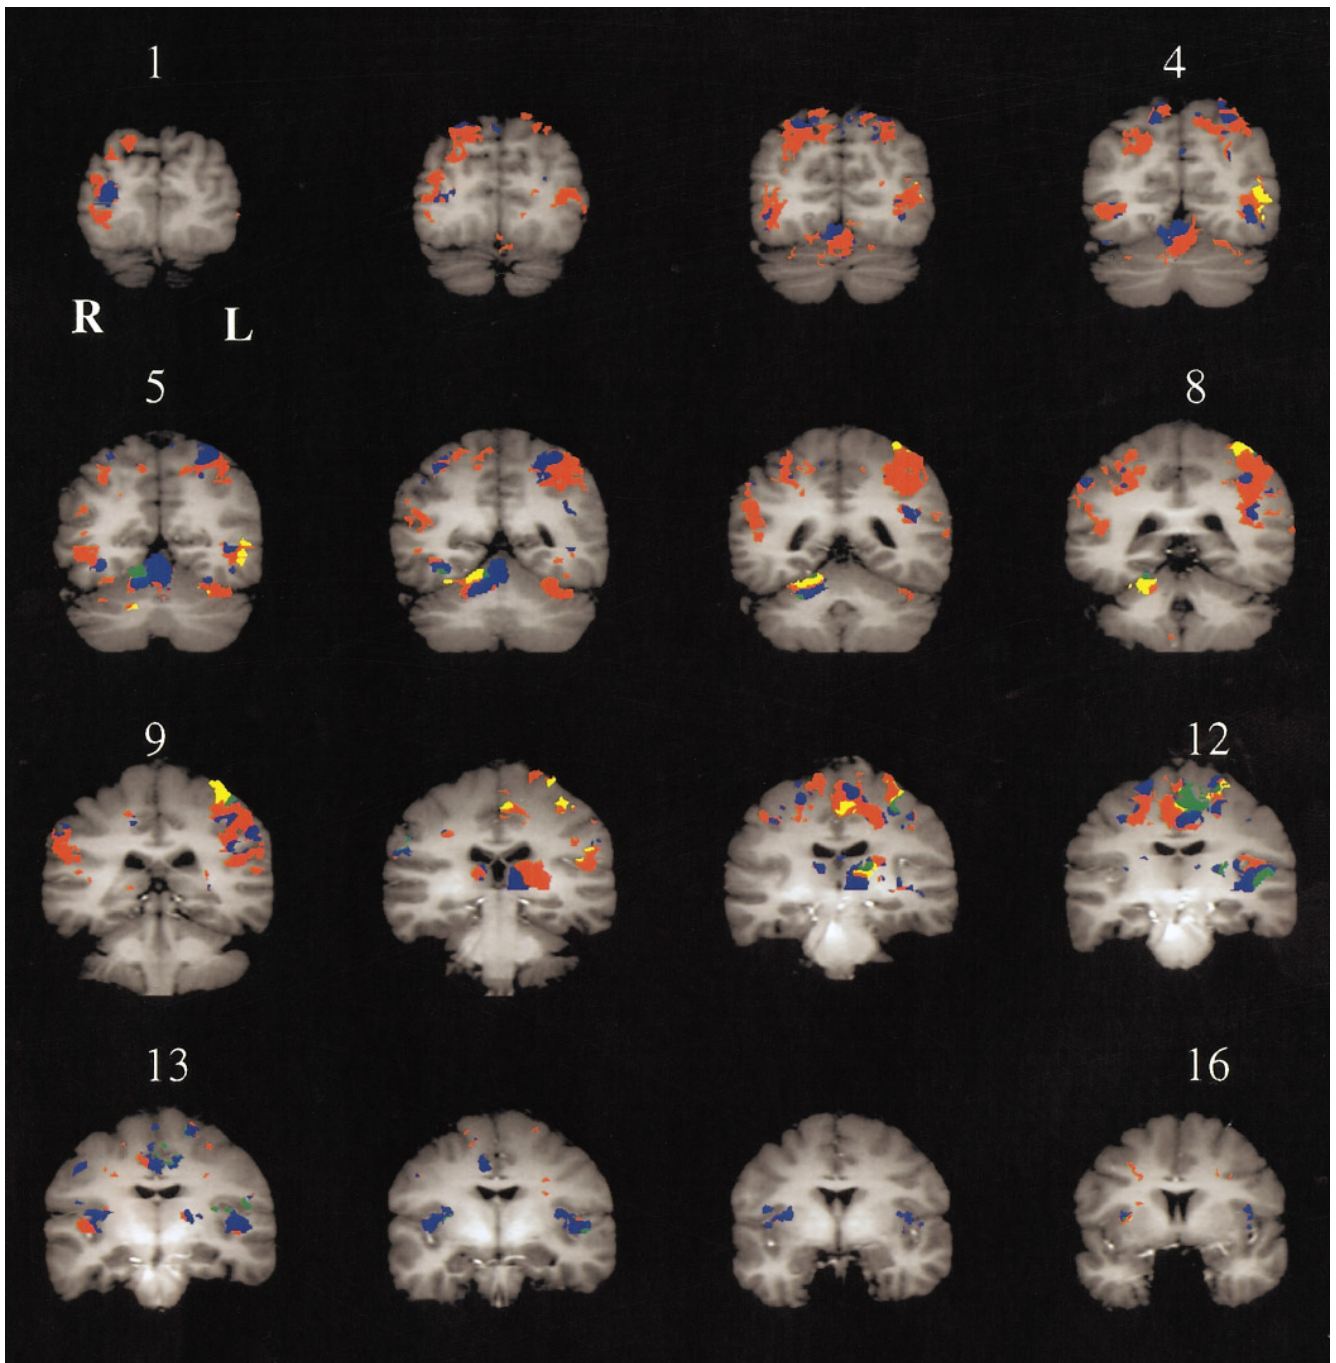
The color code in the coronal slices displayed in Fig. 5 identifies areas that were activated by the visually guided two-step task as well as one of the two other tasks performed, to delineate regions that may be accounted for by eye movements and hand/wrist directed joy stick movements without visual guidance. Areas in *blue* identify regions that were activated both in the eye movement task that overlapped with the activation in the two-step task. *Yellow* identifies regions common to the hand/wrist directed joystick movements and the two-step task. *Green* identifies regions activated in all three tasks. Remaining activation not accounted for by either the joystick movement and/or the eye movement is depicted in *red*. Coronal slices are shown in standard radiographic format (right side of image is left side of the brain).
